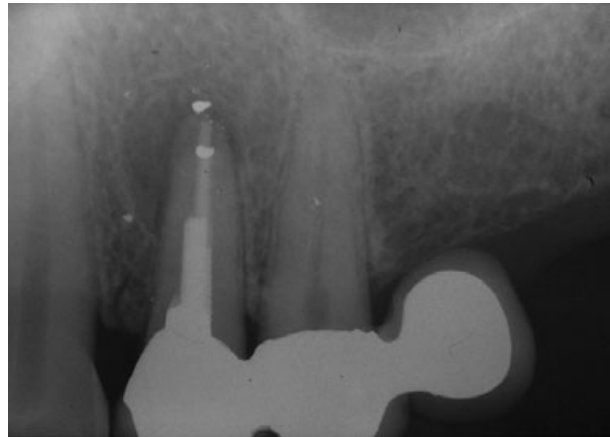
Periapical lesion associated with tooth 14 which had a history of previous periapical surgery.
